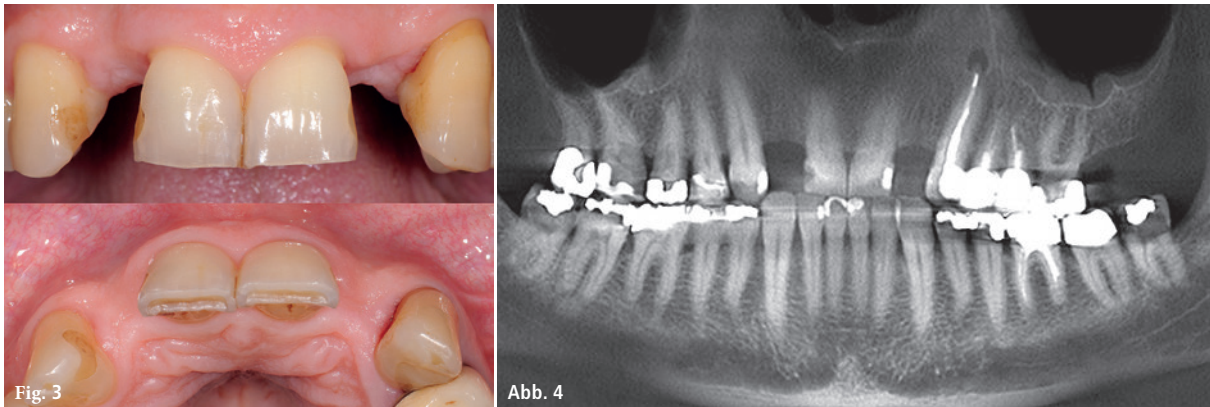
Initial situation. – Fig. 4: Initial OPG (Orthopantomogram) situation.
